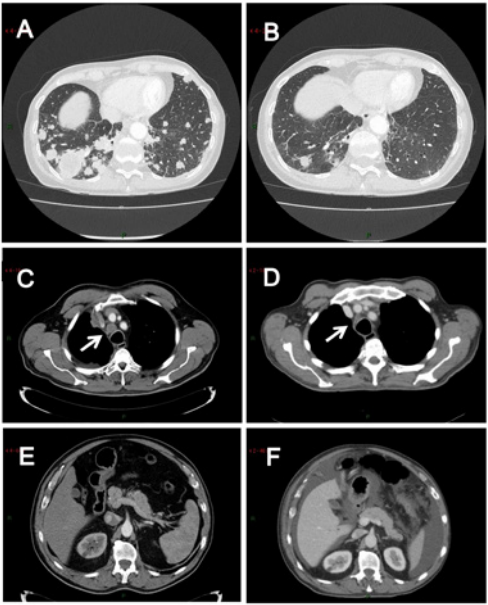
Different response patterns after treatment with crizotinib in patients with EGFR mutation positive non-small cell lung cancer and acquired cMET amplification after EGFR TKI treatment. Patient 1: Partial response to crizotinib treatment. A: Baseline CT scan demonstrating pulmonary metastases. B: Partial response on CT scan after treatment. Patient 4: Mixed response to crizotinib treatment. C: Baseline CT scan demonstrating the biopsied, cMET amplification positive, mediastinal lymph node metastasis. D: Size decrease of mediastinal and pleural metastases after treatment. E and F: Progression of peritoneal metastases and occurrence of a malignant peritoneal effusion.
